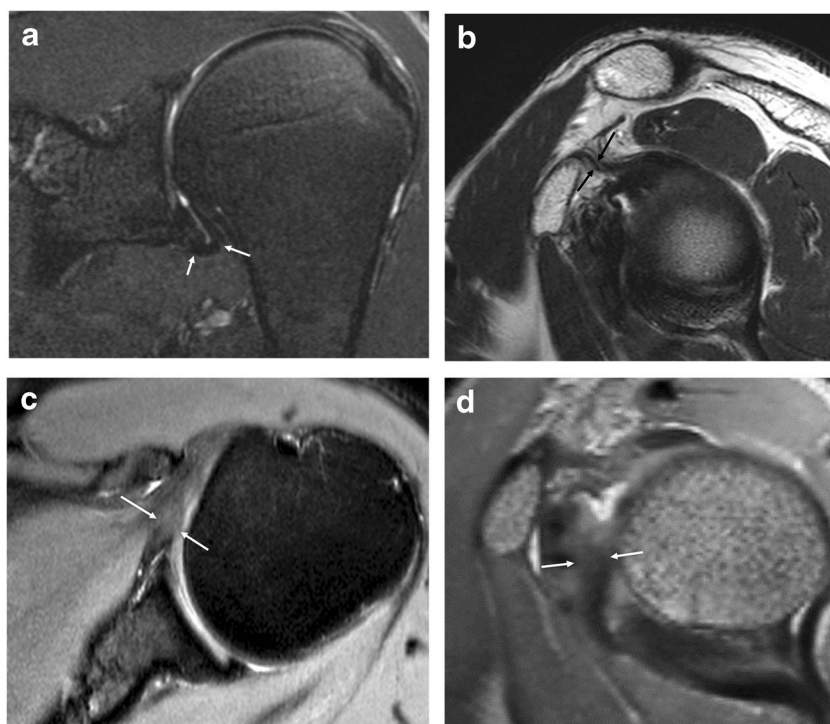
A 50-year-old man with adhesive capsulitis. a Oblique coronal fat-suppressed T2-weighted image showing no significant thickening (3.70 mm) of the axillary joint capsule (*arrows*). There is no significant axillary capsular abnormal hyperintensity either. b Oblique sagittal T2-weighted image showing no significant thickening (2.90 mm) of the coracohumeral ligament (*arrows*). c Axial fat-suppressed PD image showing thickening (6.94 mm) and abnormal hyperintensity of the anterior joint capsule (*arrows*). d Oblique sagittal PD VISTA SPAIR image showing prominent thickening of the anterior joint capsule (*arrows*)
